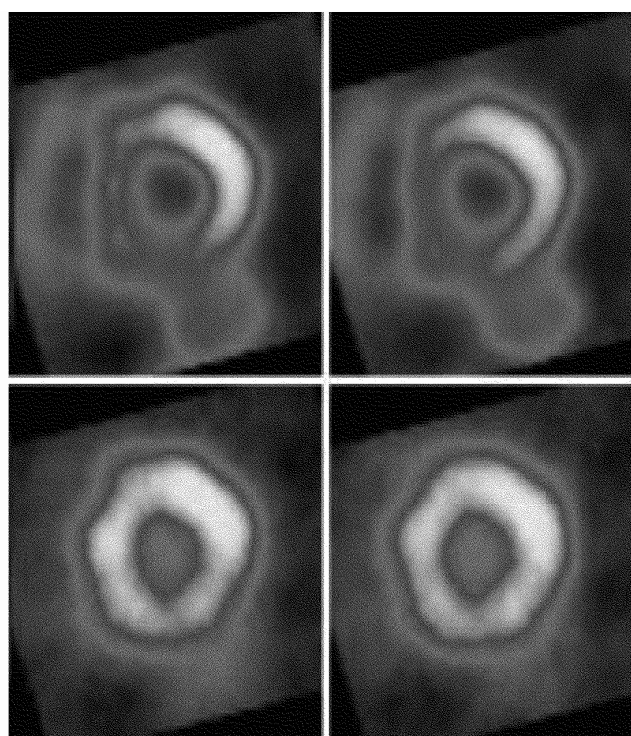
FDG-SPECT imaging to assess viability. The Tc-99m tetrofosmin SPECT study (upper panel) reveals reduced perfusion in the septum and inferior wall, whereas the FDG uptake (lower panel) is preserved in these regions (perfusion-metabolism mismatch).
